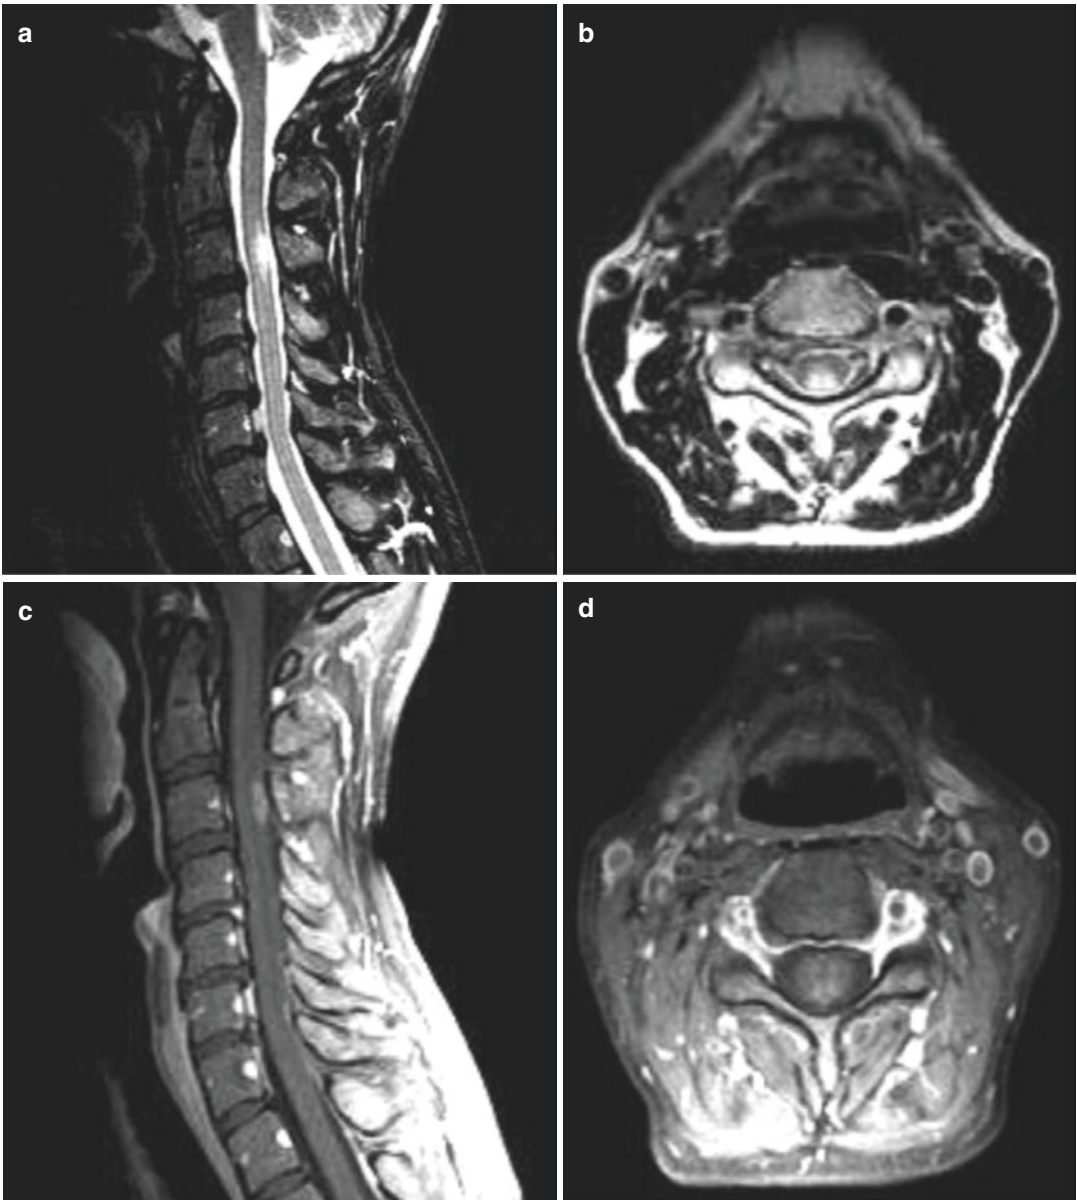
(a) Sagittal T2W and (b) axial T2W images demonstrate short segment T2 hyperintense signal abnormality in the dorsal columns of the cervical cord in a patient with multiple sclerosis. The presence of enhancement in (c) contrast-enhanced sagittal T1W and (d) contrast-enhanced axial T1W images indicates active inflammation. Patient with acute disseminated encephalomyelitis (ADEM) demonstrates abnormal hyperintense signal on (e) axial FLAIR image of the brain, as well as (f) axial T2W, (g) sagittal T2W, and (h) contrast-enhanced sagittal T1W images of the thoracic cord. There is mild
